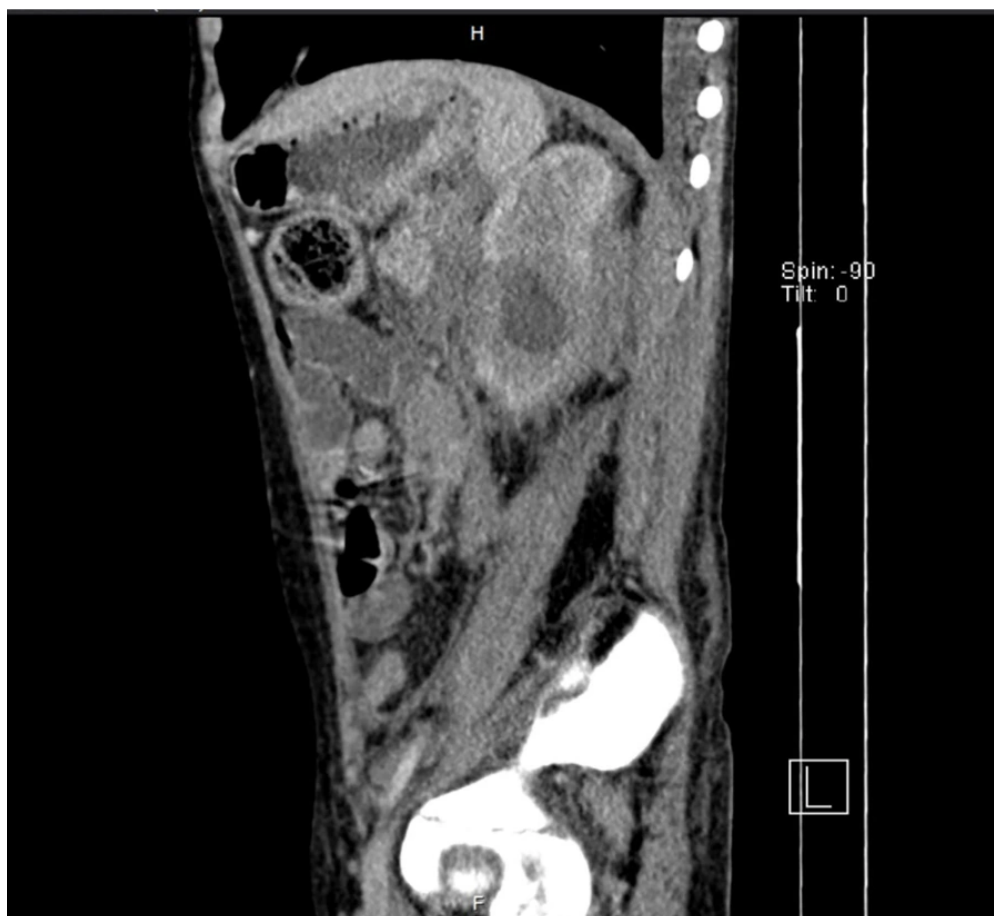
Contrast-enhanced CT demonstrating a retroperitoneal mass compressing major vessels and surrounding structures in the presented case.
